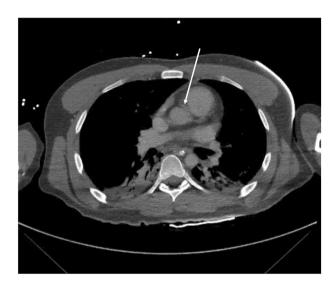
Computed tomography of the chest with contrast demonstrating an aberrant coronary artery (white arrow).
